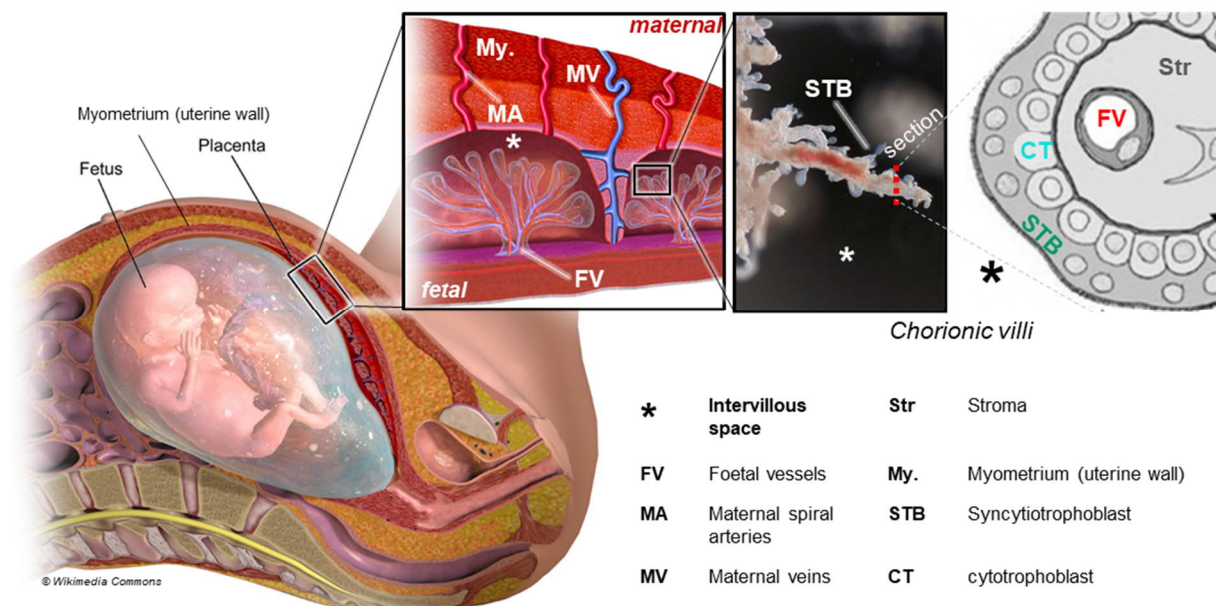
Human placenta. Human placenta showing how maternal and foetal circulation is separated by a trophoblast layer (STB: syncytiotrophoblast and CT: cytotrophoblast). Maternal spiral arteries open into the intervillous space, which surrounds chorionic villi and is filled with maternal blood. Maternal blood leaves the intervillous space via maternal veins. From the foetal side, foetal vessels in the chorionic villi create a fine network. Exchange between the two systems sees a barrier of trophoblasts, which cover the chorionic villi.
